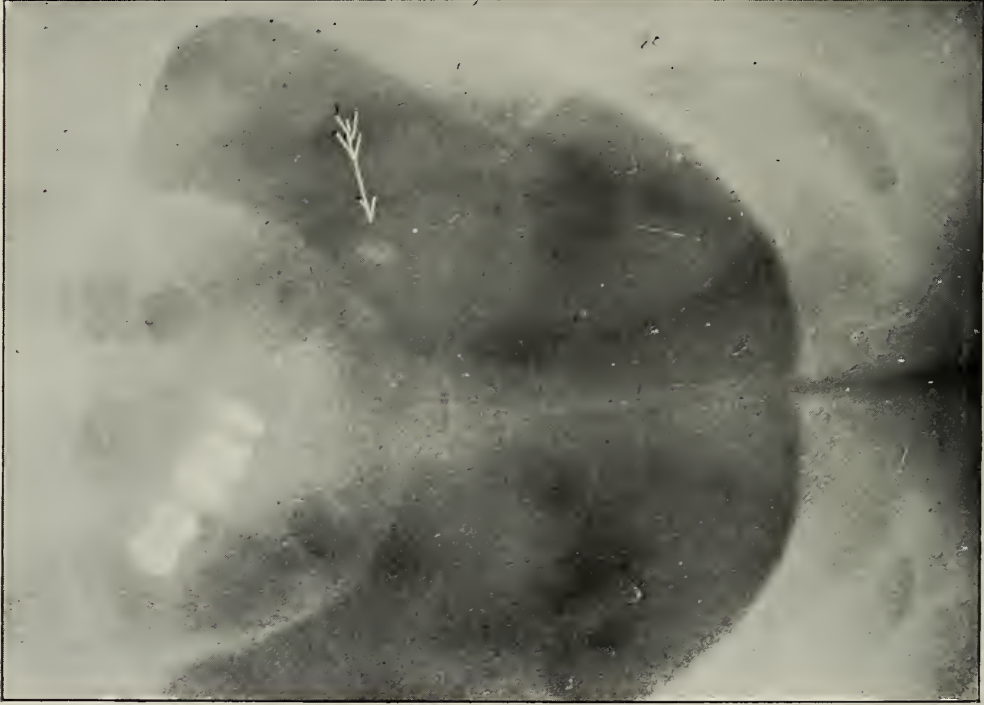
X-ray No. 12288, a. Region: left pelvic. Original plate shows suspicious shadow in region of ureteral-pelvic junction.
